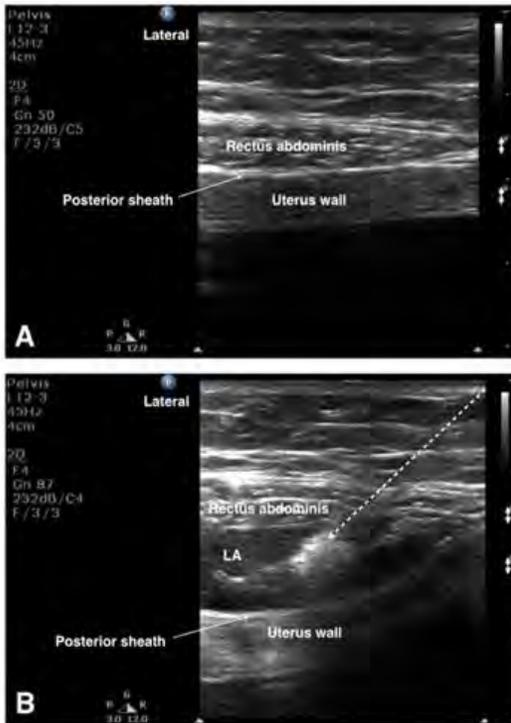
A. Ultrasound image shows the rectus abdominis muscle, the hyper-echogenic line beneath which is the posterior sheath. Inferior to the posterior sheath is the uterus wall. B. Ultrasound image shows the local anesthetic (LA) was injected in the space between rectus abdominis muscle and its posterior sheath. The dotted line represents the needle pathway.
